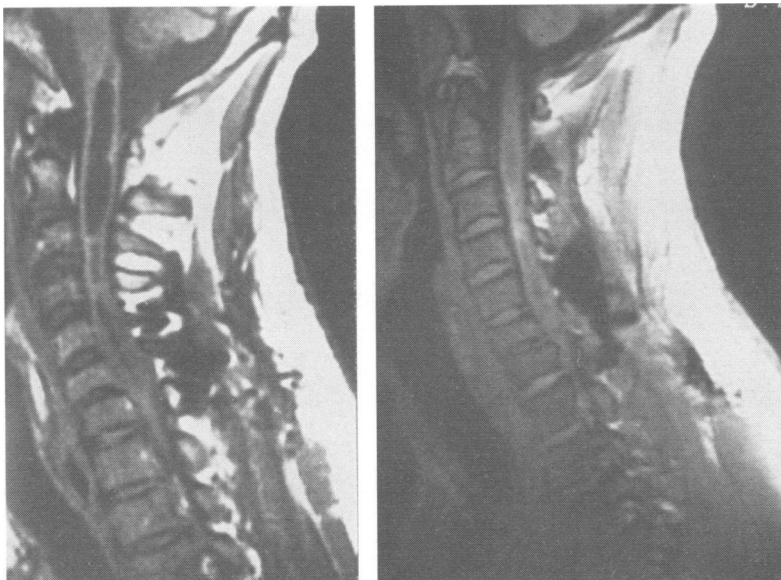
Figure MRI of cervical spine. Left: study performed on admission showing a large syrinx of the cervical cord extending into the medulla; right: study performed at one year showing almost complete collapse of the syrinx.
